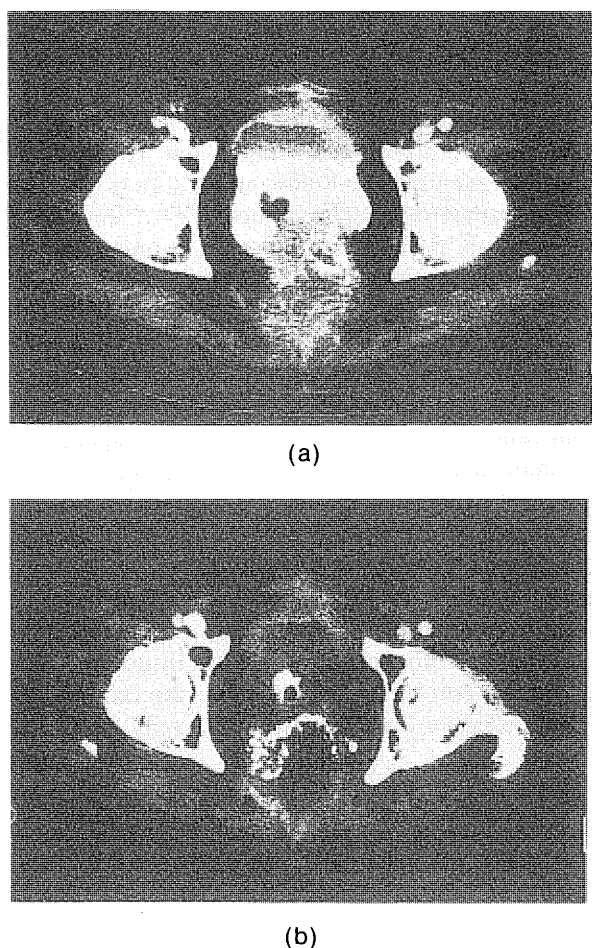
(a) CT scan of a recurrent rectal cancer invading the bladder. This tumor received a total of 66 Gy of irradiation in combination with 14 sessions of RF capacitive hyperthermia ( $T_{av} = 43.9^{\circ}\text{C}$ ). (b) Although no tumor regression was noted 3 months after the combined treatment, a marked low density area was demonstrated by CT scan. Needle biopsy performed at this time revealed coagulation necrosis and fibrosis, without any viable tumor cells. This tumor had not regrow by 10 months after the treatment when the patient died of distant metastases.
